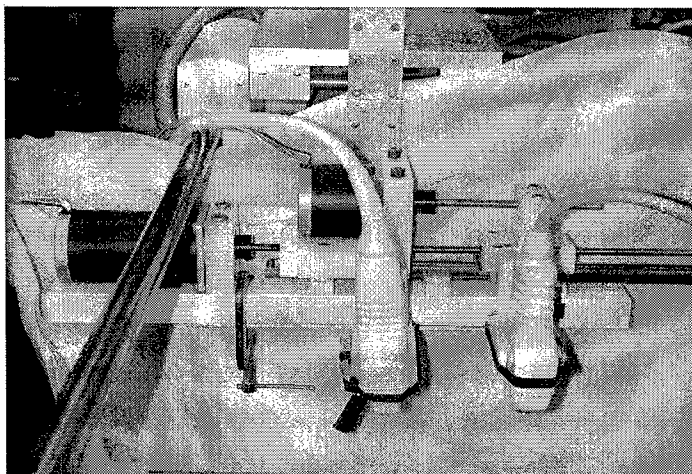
Dual-transducer apparatus. Two stepper motors turn two threaded rods parallel to each other to move the ultrasound transducers, held by the transducer holders which translate on a guided slide. The separation motor, mounted upon a stand, adjusts transducer separation. The stand in turn is translated by the larger translation motor, which controls the sweeps over the volume of interest. For the experiments presented, the complete apparatus was placed within a rubber-lined water tank upon a stand, and cables connect the motors to a control box (not shown), which provided drive power and was in turn controlled by a laptop computer using the DAQCard-700 and LabVIEW scripts.
